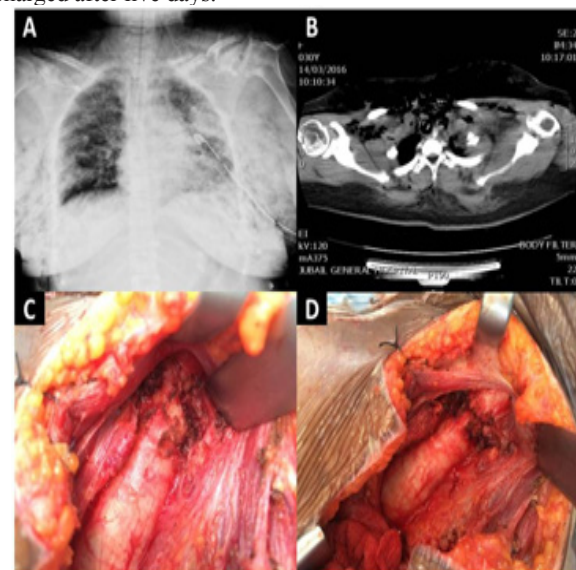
(A) Chest-x-ray showing subcutaneous emphysema. (B) CT scan thorax revealed anterior tracheal tear, pneumomediastinum and subcutaneous emphysema. (C) Operative finding: first ring fracture and funnel shape trachea. (D) Second tracheal ring anastomosed to cricoid cartilage.
